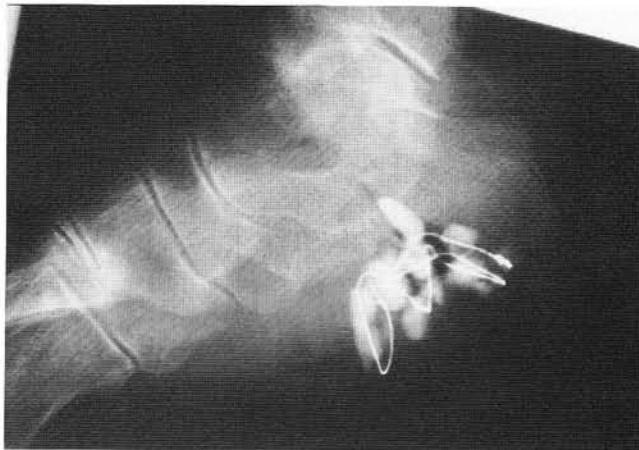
Postoperative radiograph revealing the beads in place.
